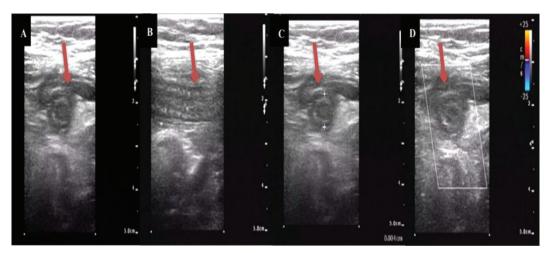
Ultrasound data of the right lower abdominal cavity (appendiceal region) in a 35 years old female patient. Cord-like hypoechoic wall was (A, B), hypoechoic wall in the periphery (C), side of the cavity (D). Note: A-C is 2D ultrasound; D is color Doppler flow imaging.
